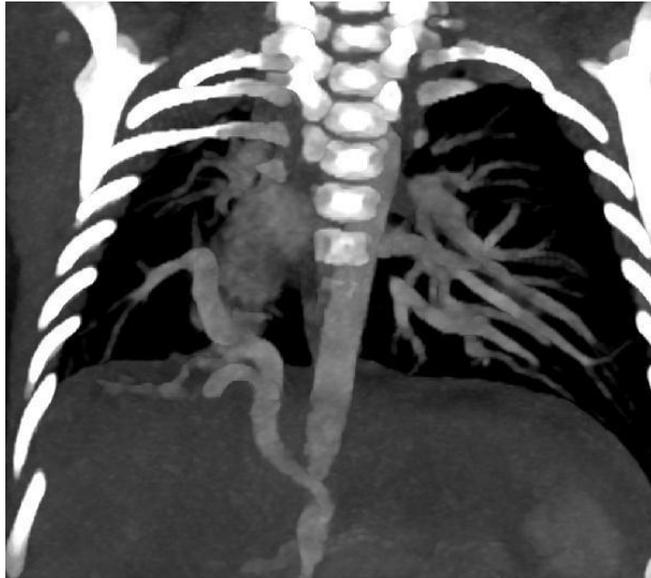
CT scan of the chest coronal reformatted view showing a systemic artery arising from common celiacomesenteric trunk supplying the right lower lobe.
